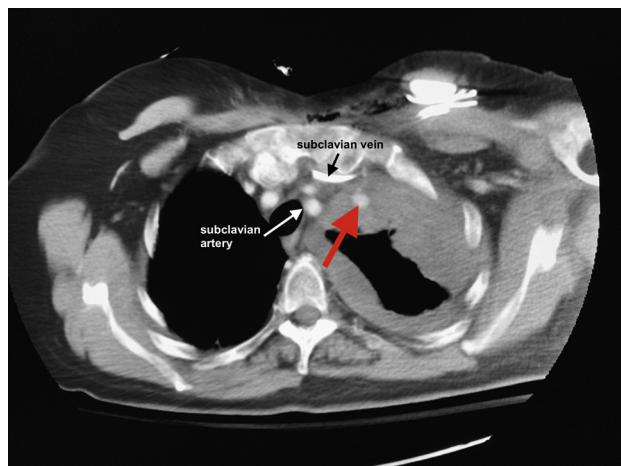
Axial view of a contrast-enhanced computed tomography scan showing extravasation of contrast (arrow) from the left internal mammary artery into a pseudoaneurysm.
